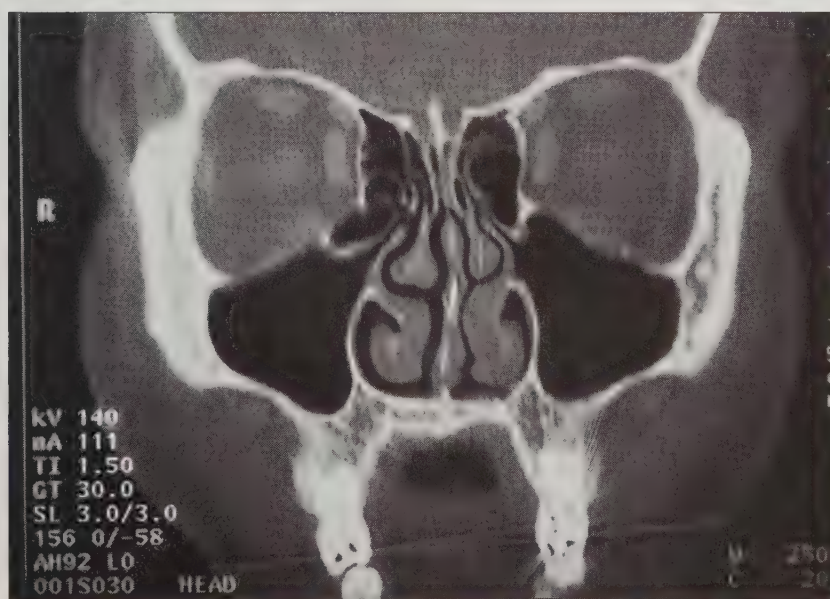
CT scan of normal midfacial anatomy.
